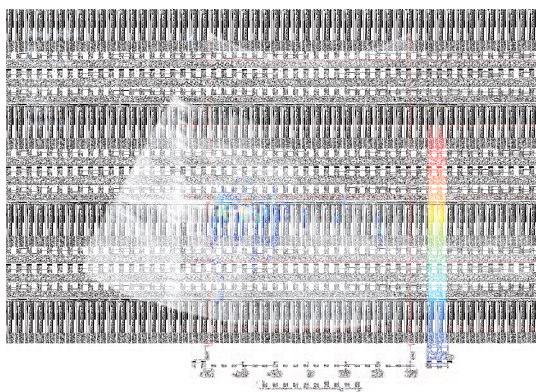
Reconstructed cavitation image displayed on the top of an background ultrasonic B-mode image
